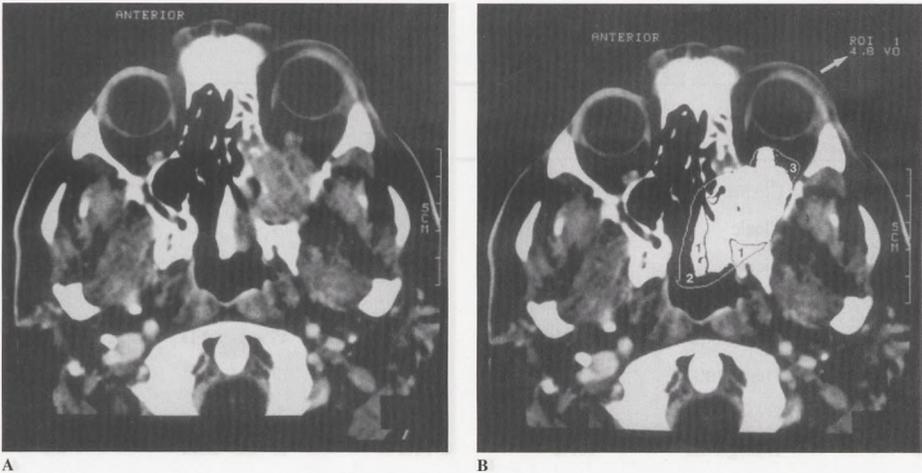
CT axial section of a patient with ethmoidal sinus carcinoma. (A) Plain CT section showing carcinoma of the left ethmoid sinus, extending into the nasal cavity and invading the left orbit. (B) Tumor volume analysis using the volume measurement function. Automatic exclusion of bone-, air-, and fat-densities simplifies outlining the tumor. General outlining of tumor boundaries suffices. Only the bright pixels are included in the volume analysis. 1: automatic exclusion of bone (nasal septum, and part of left pterygoid plates). 2: automatic exclusion of air in nasal cavity. 3: automatic exclusion of orbital fat. The calculated volume in this section is 4.8 cm^3 (straight arrow). Note: this patient was not included in the study, but selected to demonstrate the volume analysis technique.
